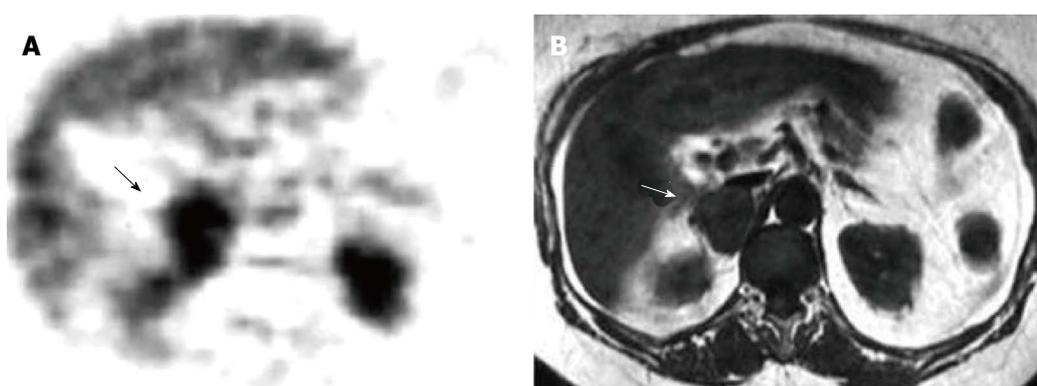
Right adrenal metastasis by melanoma. A: Axial fluorine-18 fludeoxyglucose-positron emission tomography scan detects abnormal focal uptake in the right adrenal region (black arrow) where a large adrenal metastasis was detected by magnetic resonance (MR); diffuse normal liver tracer activity is detectable; physiologic tracer activity is also detectable in kidneys; B: T1-weighted axial MR detects a right adrenal tumor hypointense compared to liver signal intensity (white arrow).
